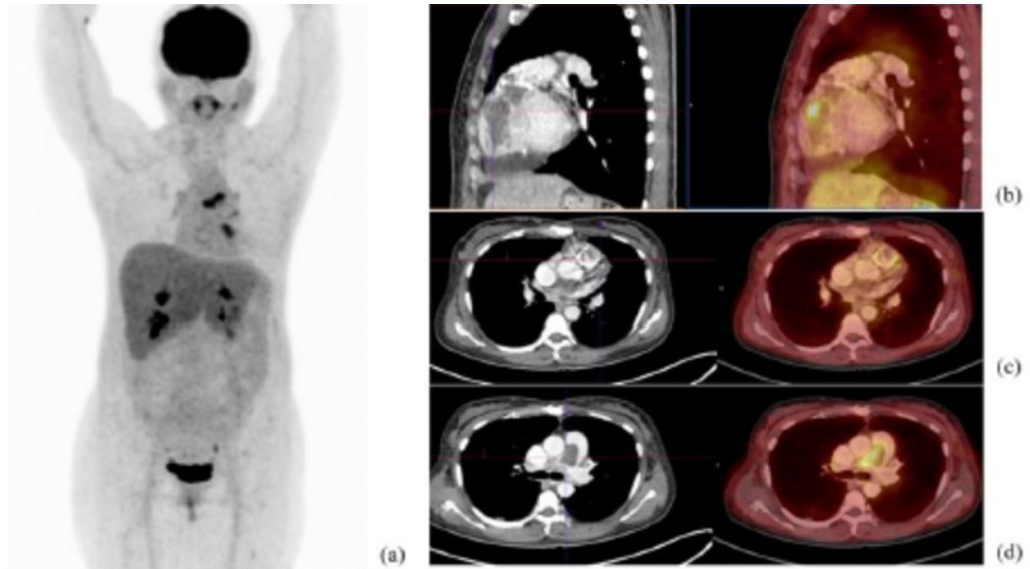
FDG PET/CT scan of a 45 year-old female pulmonary artery leiomyosarcoma patient (a) shows recurrent hypermetabolic tumor occupying in the right ventricle, right ventricular outflow tract (b) and pulmonary valve ring (c). Also seen another one skip malignancy at the pulmonary trunk and right main pulmonary artery (d).
